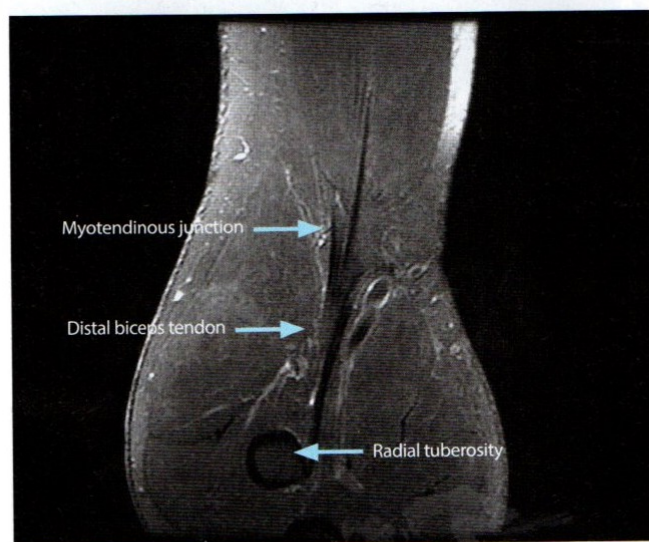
MR image captured using the DOC technique demonstrating typical distal biceps tendon attachment with visualization of the myotendinous junction. Image courtesy of the authors.
